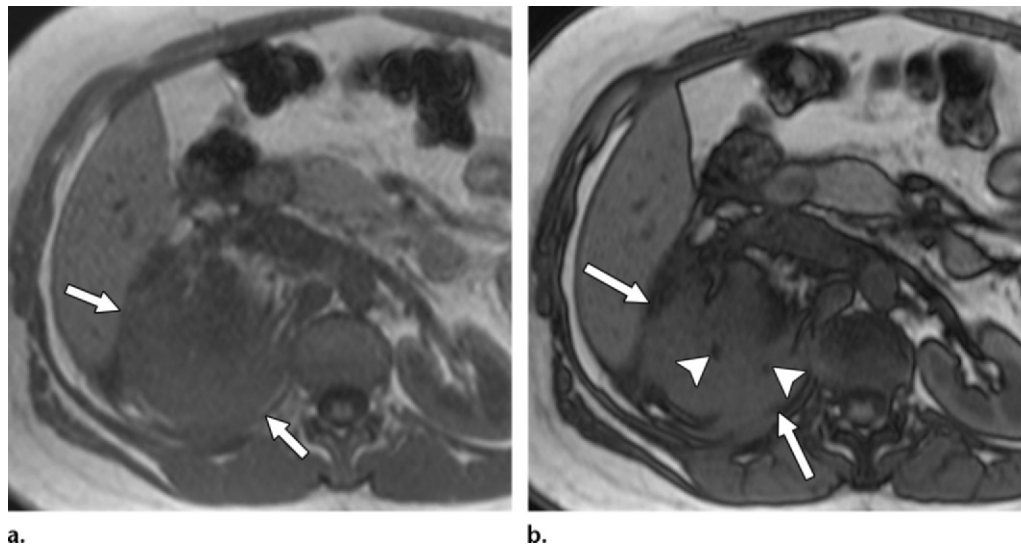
Adrenocortical carcinoma in a 53-year-old man. Axial in-phase (a) and opposed-phase (b) T1-weighted MR images show a right adrenal mass (arrows). Foci of signal intensity loss seen on the opposed-phase image (arrowheads) are due to intracellular fat content.
